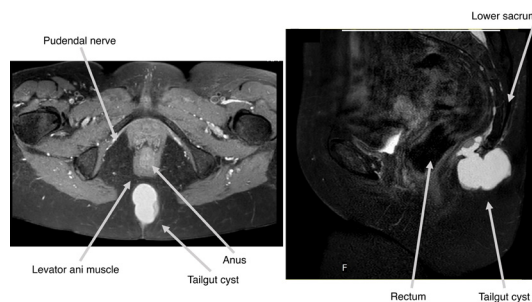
Sagittal and axial views of the diagnostic MRI showing the retrorectal cyst and their anatomical relations.
